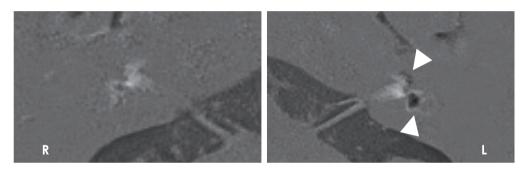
Magnetic resonance imaging (MRI) performed 4 h after intravenous injection of gadolinium hydrate A 69-year-old man with left Meniere's disease shows significant endolymphatic hydrops on the left side on MRI (white arrowheads).
